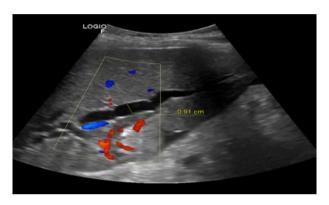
Hepatic ultrasound showing intrahepatic biliary dilation measuring 91 mm.
